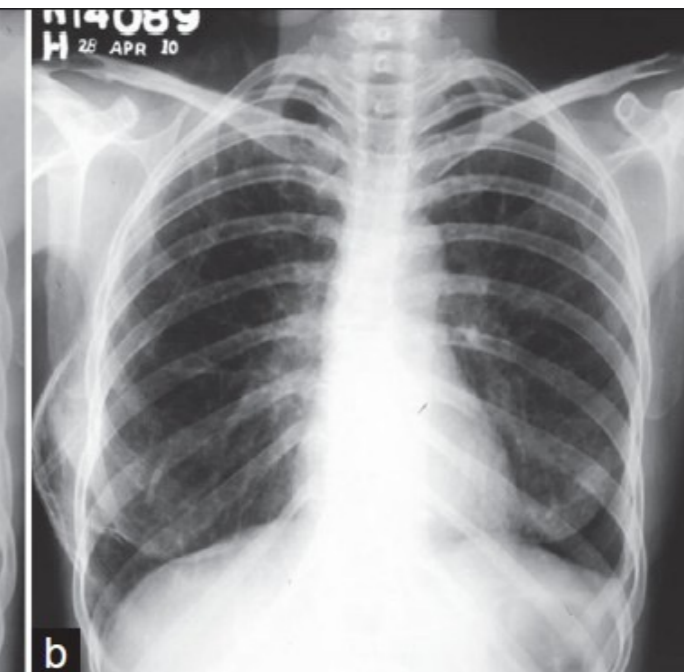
Chest X-ray with intercostal tube in situ and fully expanded right lung
